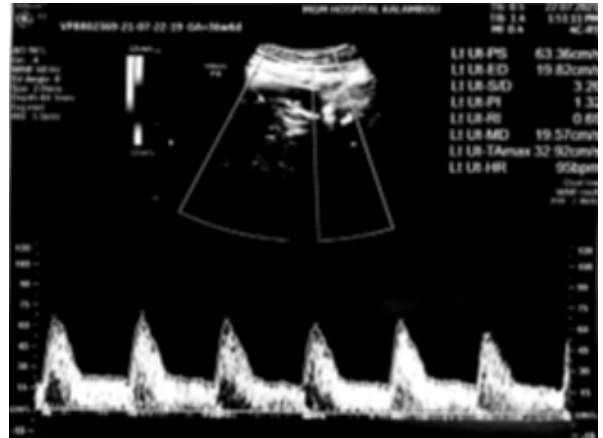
Abnormal Left Uterine Artery Doppler Sonogram
